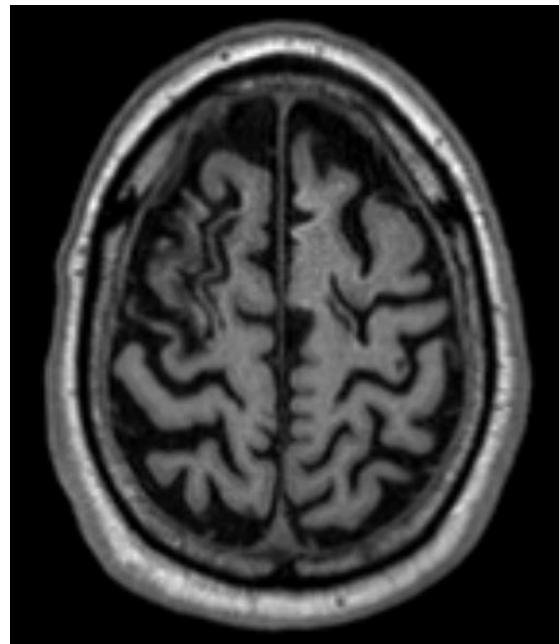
Cranial MRI Scan (T1) - First psychiatric hospitalization, two months after bilateral stroke
